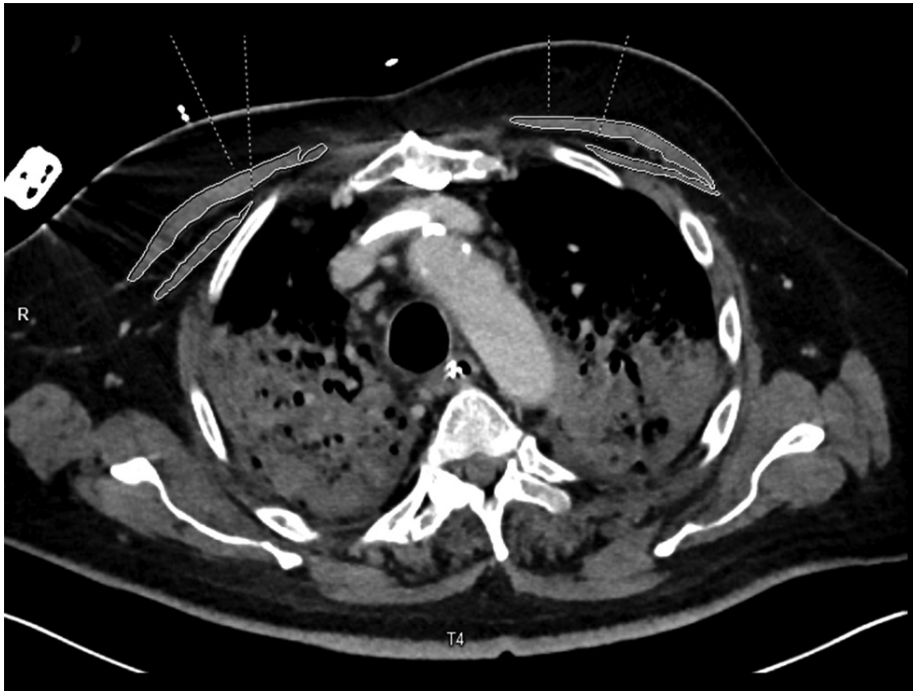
Thorax-CT eines 67-jährigen Patienten. Die identifizierten Muskelparameter waren: PMA 18,0 cm<sup>2</sup>, PMI 5,8 cm<sup>2</sup>/m<sup>2</sup>, Muskeldichte 22,5 HU, SMG 132,3. Der Patient starb nach 13 Tagen auf der Intensivstation.
